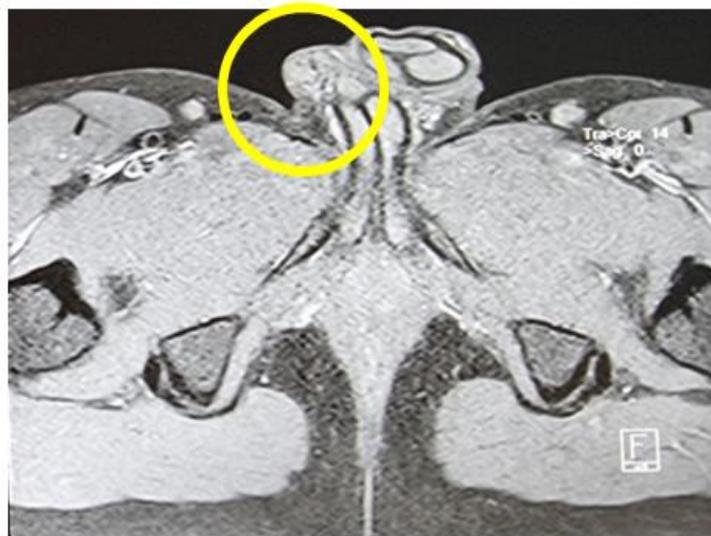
MRI with axial section shows right testicular hypotrophy
